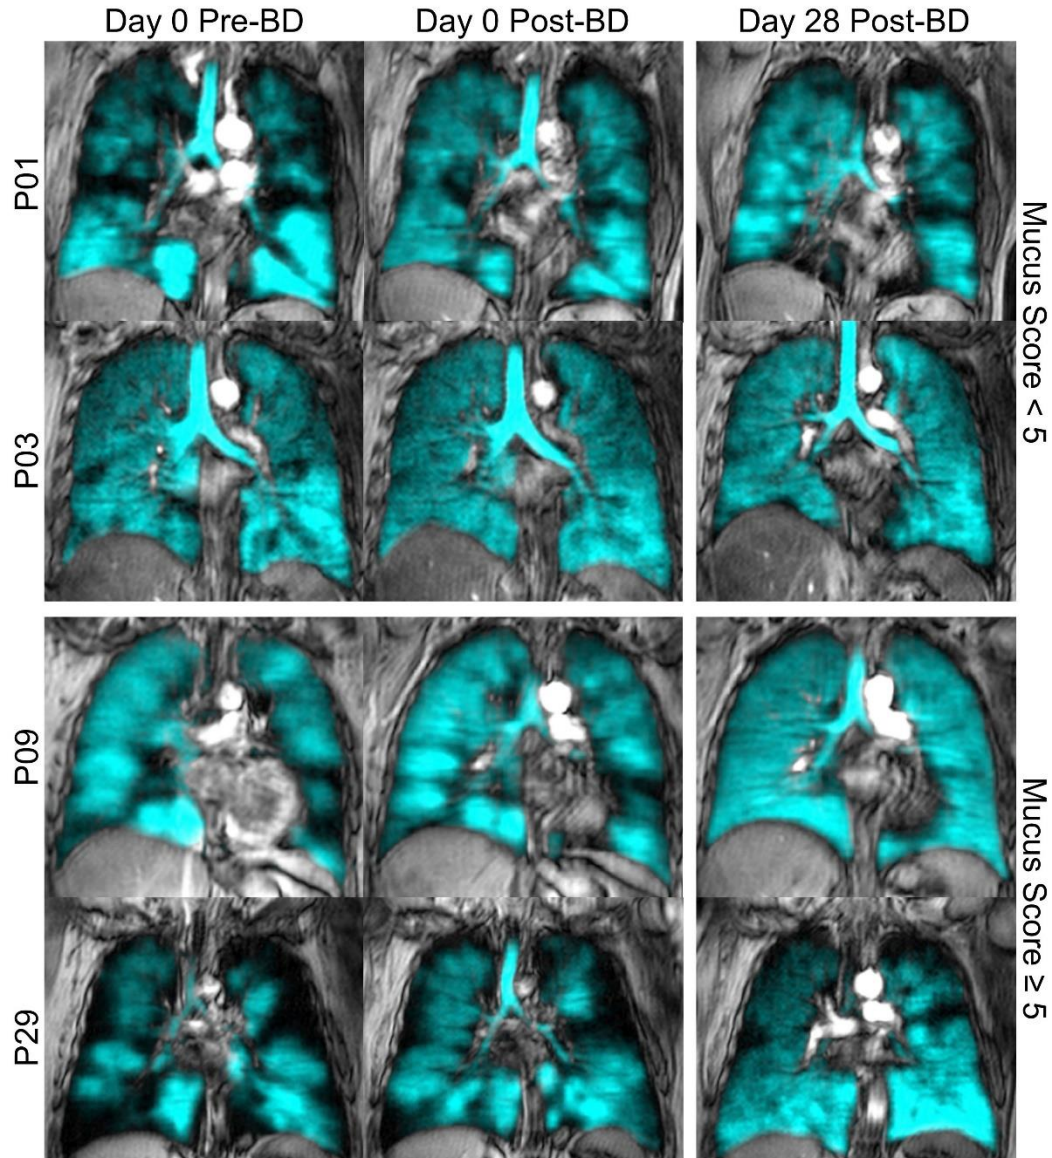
Representative ^{129}Xe MRI on Day-0 and Day-28
